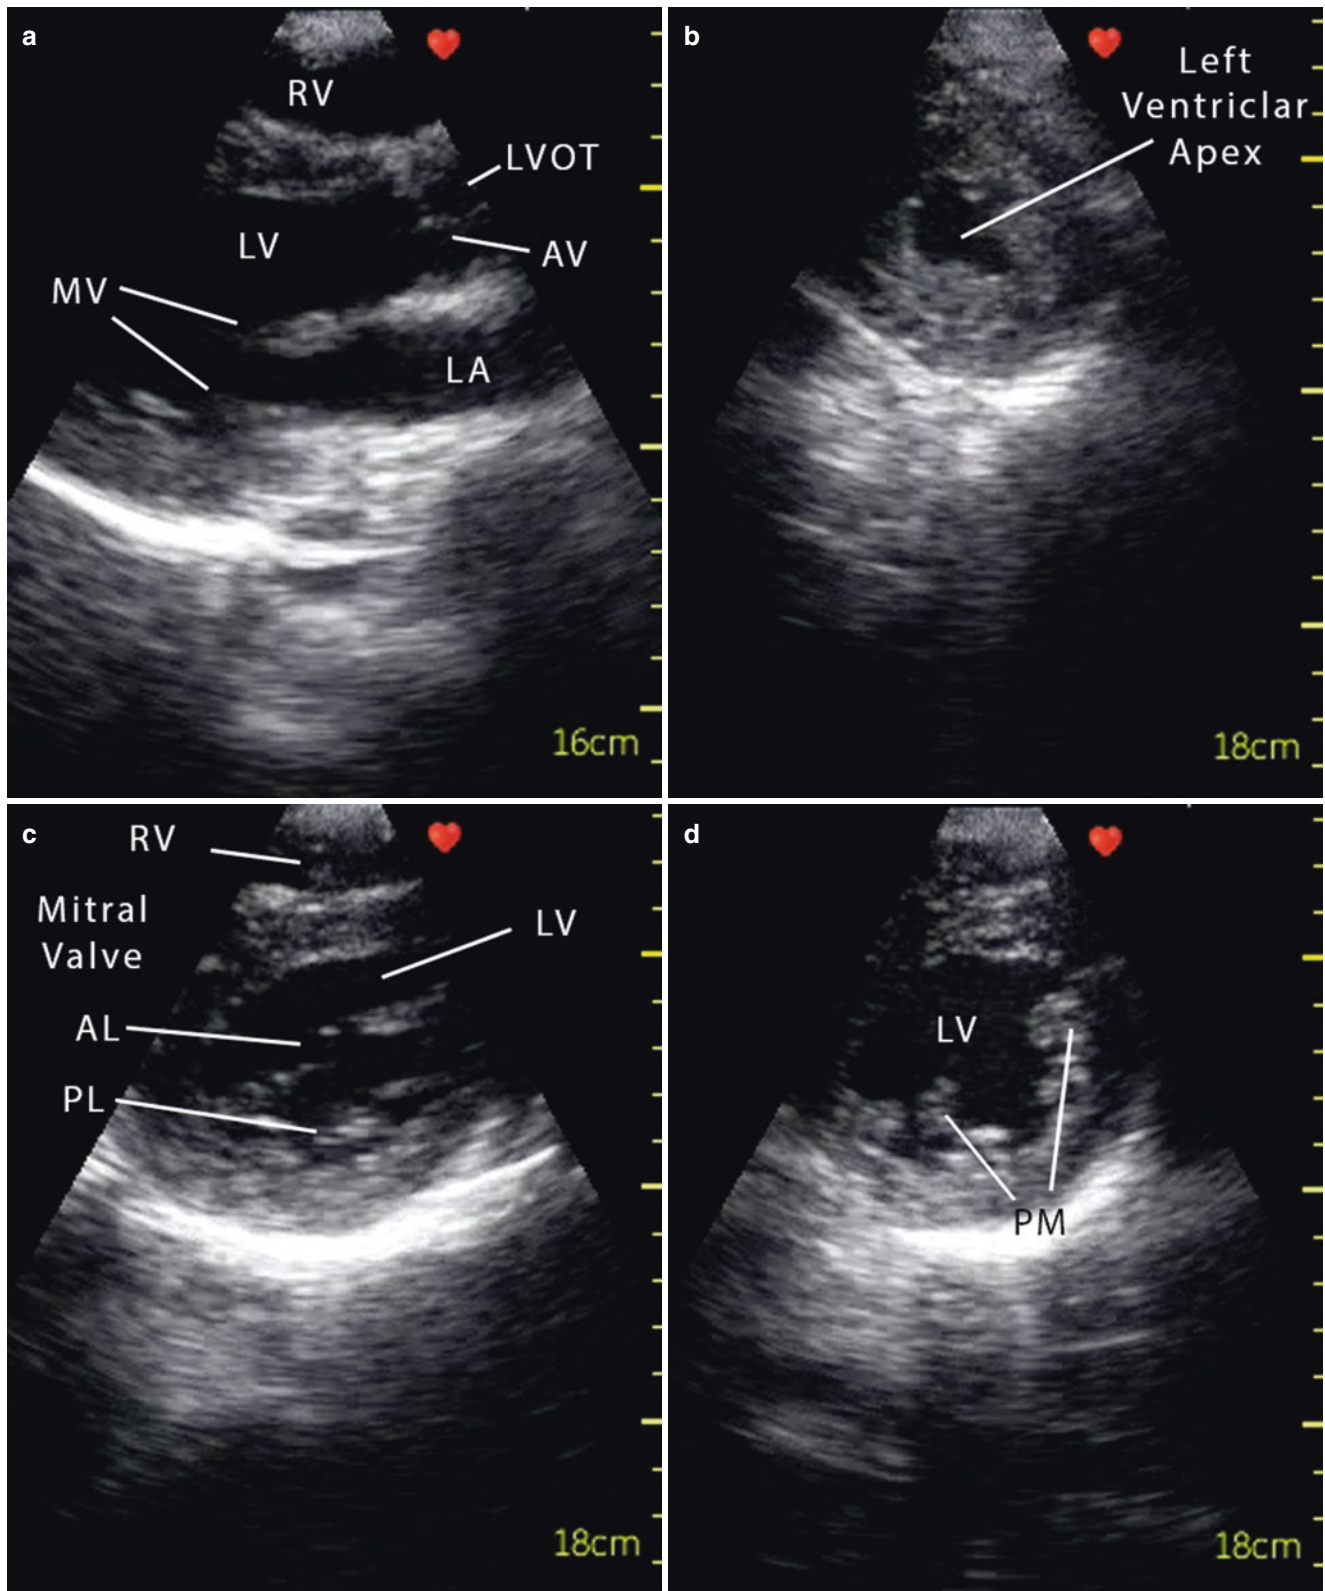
(a) Parasternal long axis (PLAX) view of the left ventricle (LV). *RV* right ventricle, *LVOT* left ventricular outflow tract, *LA* left atrium, *MV* mitral valve. (b) Parasternal short axis view of the left ventricle, apical region. (c) Parasternal short axis view of the left ventricle, mitral leaflet level (base of the heart). *LV* left ventricle, *RV* right ventricle, *AL* anterior leaflet, *PL* posterior leaflet. (d) Parasternal short axis
